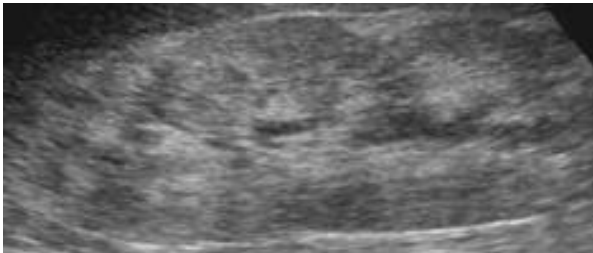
Ultrasound Kidney image
